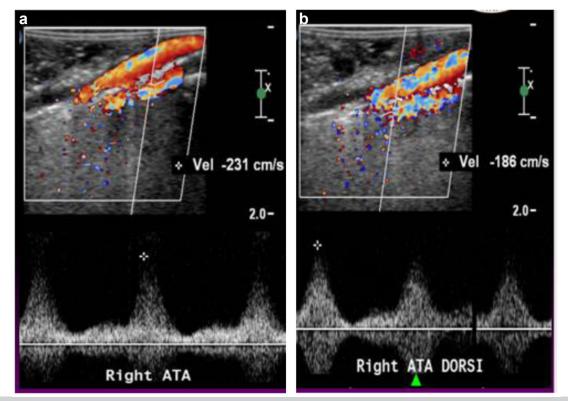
Intraoperative duplex ultrasound examination of the right anterior tibial artery (*ATA*) after surgical release. (A) At rest. (B) Passive dorsiflexion.
